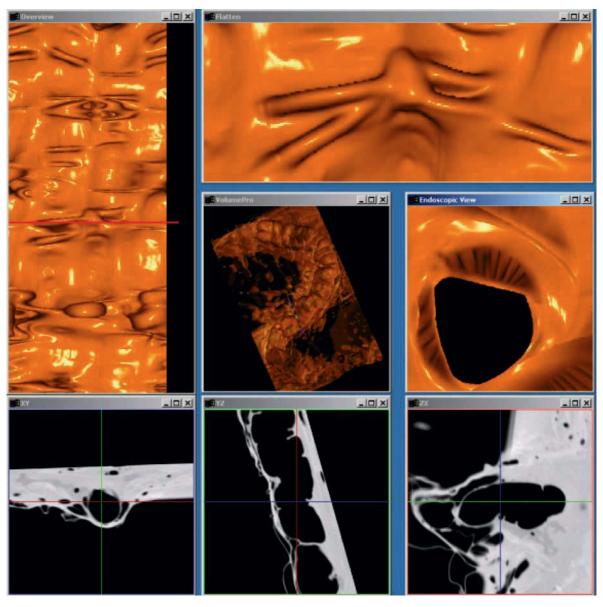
Interactive application for evaluation of virtual dissection using the 3D local flattening approach. Seven different windows are shown on the computer screen: left upper corner: virtual dissection of the colon using the 3D local flattening approach (constant angle sampling). The *red vertical line* depicts the position of the virtual camera, which is used for anatomic cross-referencing on the ohter views. Upper right corner: magnified view from the left. Middle row, center: view from above. Middle row, right: virtual endoscopic view. Lower row: axial CT slice and multiplanar reconstructions (coronal, sagittal) at the position of the virtual camera. Whenever the position of the virtual camera is moved upwards or downwards with the cursor keys, all windows are updated automatically
